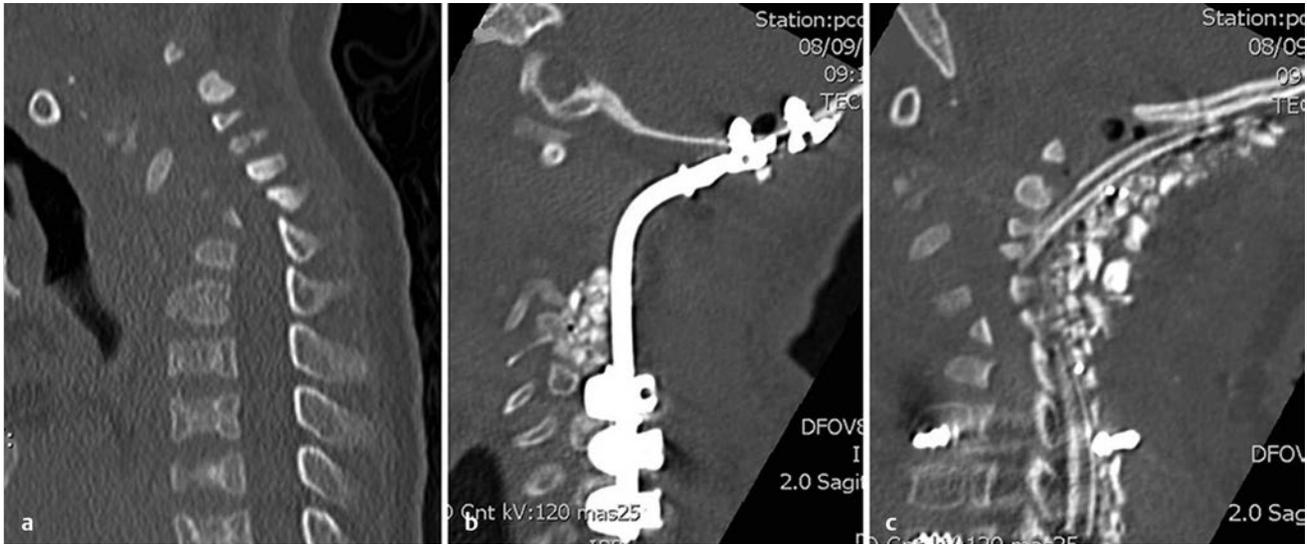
A 4-year-old girl with chondrodysplasia punctata. (a) Sagittal computed tomographic (CT) scan showing significant bone loss in the upper cervical and midcervical spine. (b) Postoperative sagittal CT scan showing occipitocervical fusion instrumentation. (c) Midline sagittal CT scan showing postoperative fusion mass.
